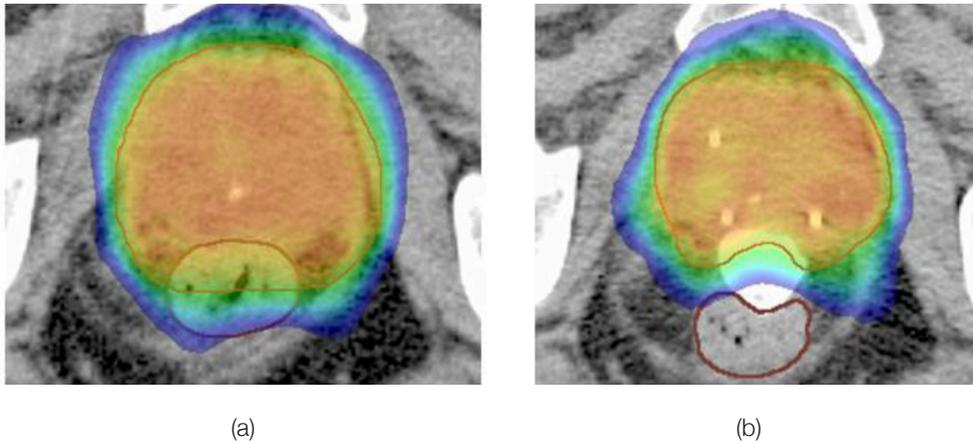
Isodose distribution in an axial CT plane before (a) and after rectum balloon implant (RBI) implantation (b) in the same patient. The image on the left shows the high-dose region >80% (green) overlapping the entire part of the rectum (brown), whereas with the RBI in situ the high-dose region is not in the rectum. The 65% isodose contour (blue) overlaps the entire rectum in (a), whereas there is no overlap in the rectum in (b).
